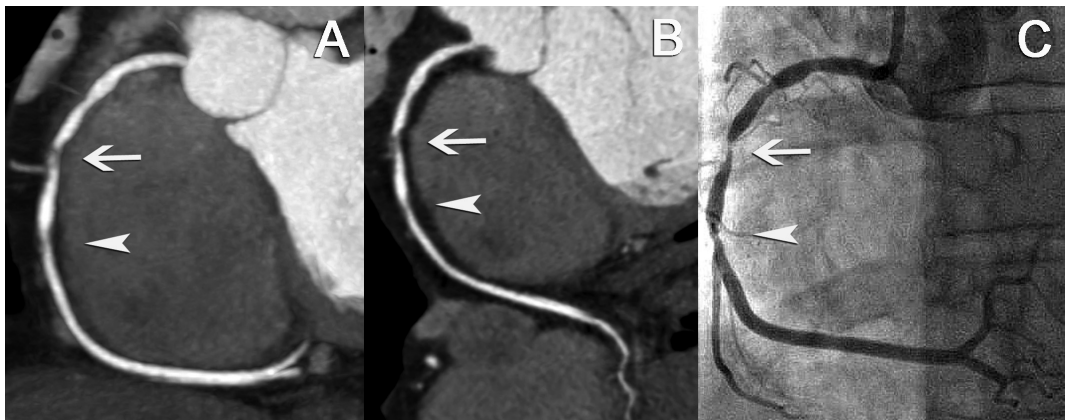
A thick maximum intensity projected CT coronary artery (CTCA) image (A) reveals the anatomy of the right coronary artery (RCA). A curved multiplanar reformatted image (B) discloses a significant coronary stenosis (arrow) in the mid right coronary artery and distally an intermediate coronary stenosis which both were corroborated by conventional coronary angiography (C).
